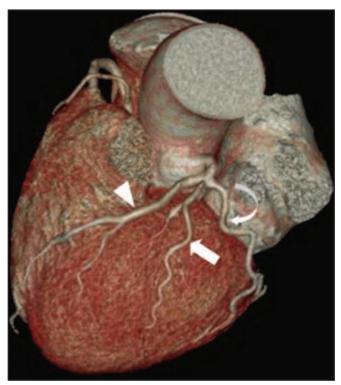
A 3D volume-rendered CT angiography showing ramus intermedius (arrow) identified between the LAD (arrowhead) and LCx (curved arrow).
